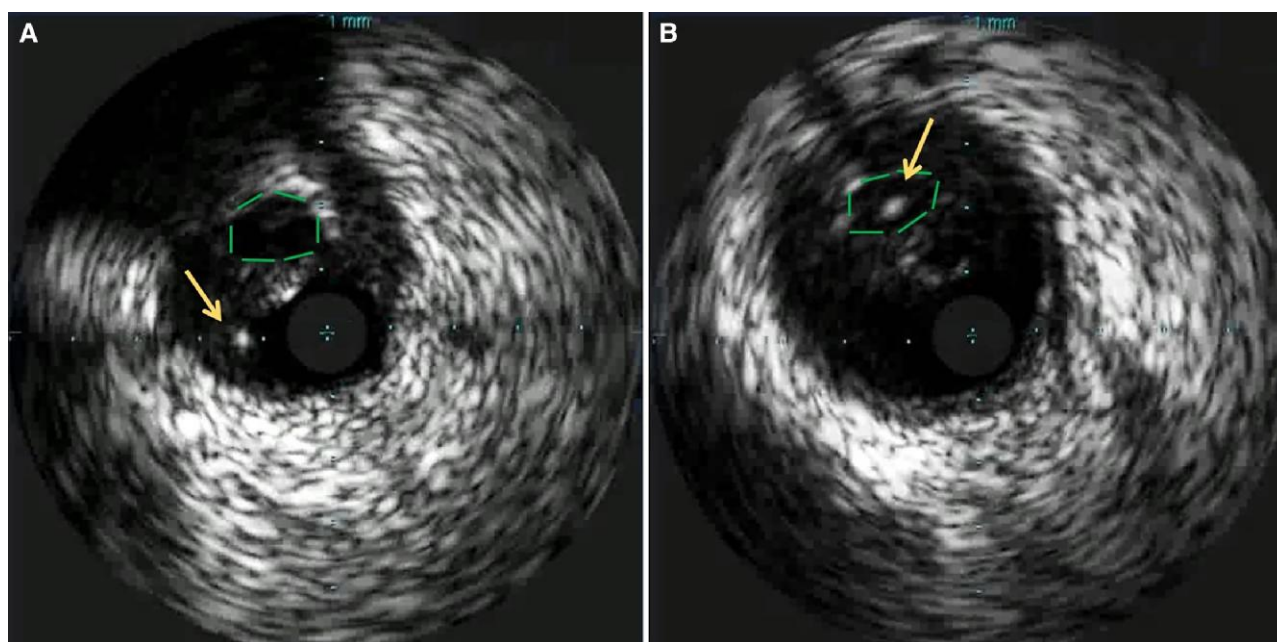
Intravascular ultrasound (IVUS) imaging displaying the IVUS catheter in the false lumen (FL) and the true lumen (TL) (broken line) compressed to one side. (A) Guidewire position in the FL (arrow). (B) After multiple attempts, we reached to introduce the wire in the TL (arrow).
